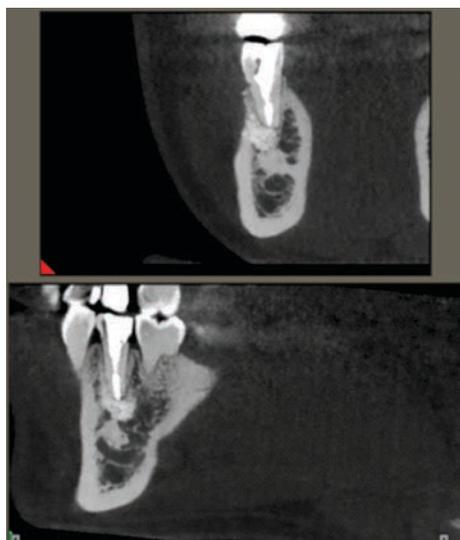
CBCT scan revealing the reconstruction of the buccal plate and periapical area after 2 years' follow up
